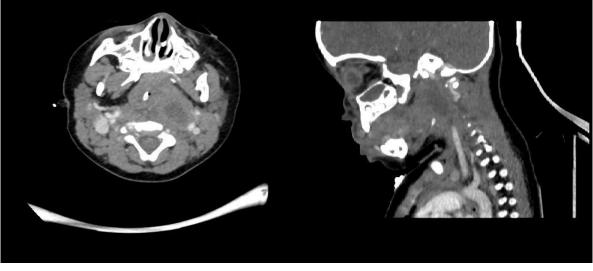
Magnetic resonance images of the retropharyngeal absscess.
